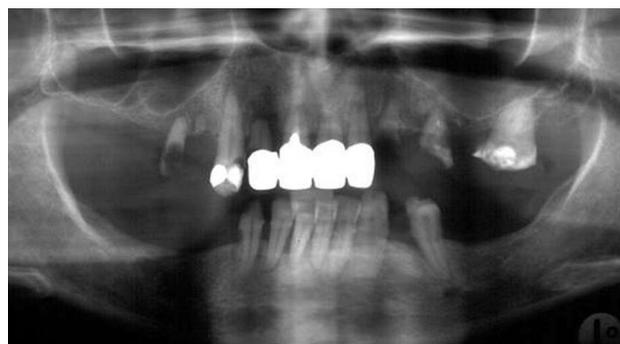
Pre-surgical panoramic radiographs
